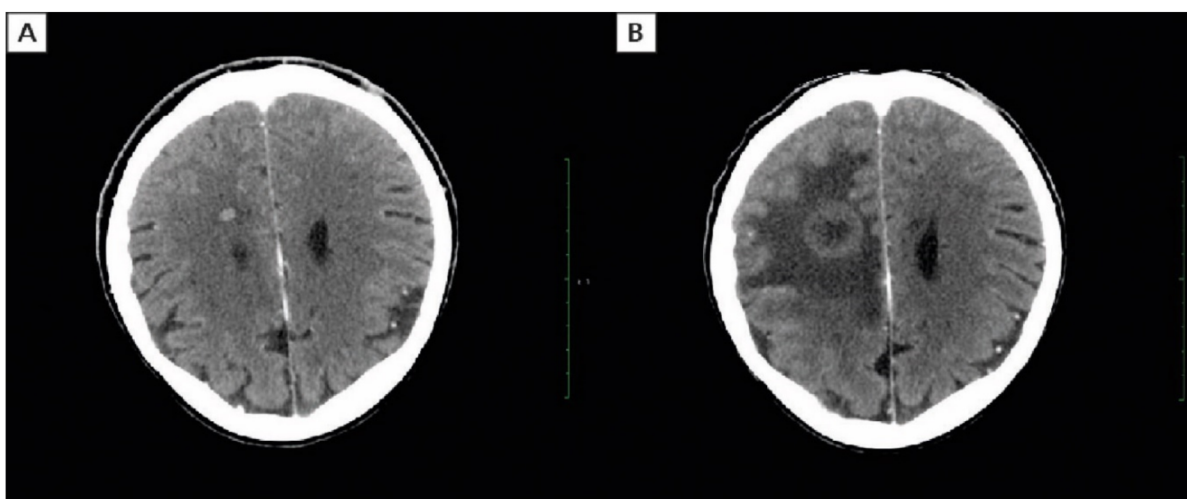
A. High-resolution brain computed tomography showing a single lesion of the left parietal lobe in August 2021; B. High-resolution brain computed tomography showing progression of brain metastases during sotorasib therapy
